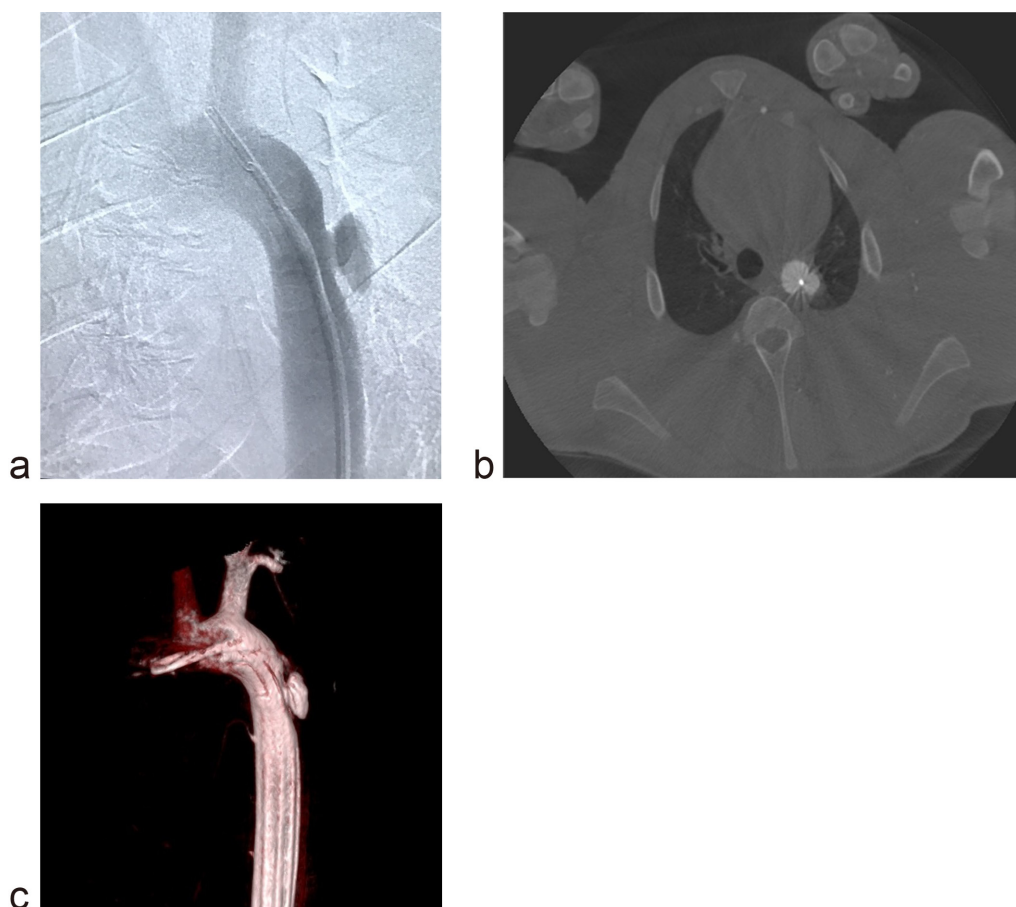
a. Aortography shows a saccular dissected thoracic aortic aneurysm. b. Computed tomography (CT) shows a patent dissected saccular thoracic aortic aneurysm. c. Three-dimensional CT shows a saccular dissected thoracic aortic aneurysm.
